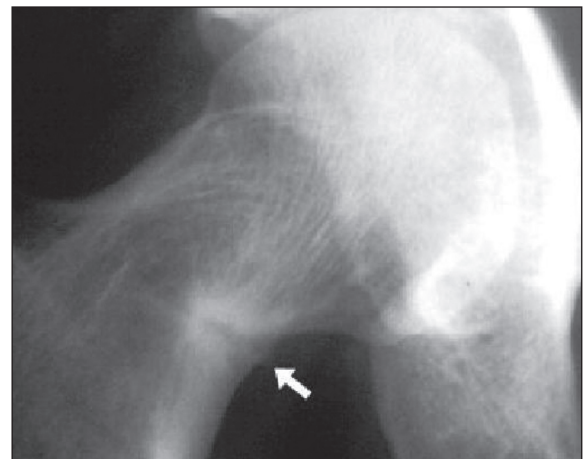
Radiograph showing looser zone (arrow) in the femoral neck of an adult with osteomalacia
